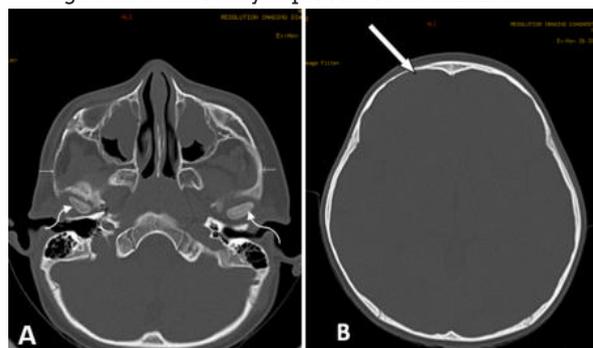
(A) & (B). Axial bone window CT image (A) showing thinning of right zygomatic arch (white arrows) and condylar process of mandible on right side (curved white arrow) and Axial bone window CT image (B) showing thinning of right frontal bone (white arrow head).
